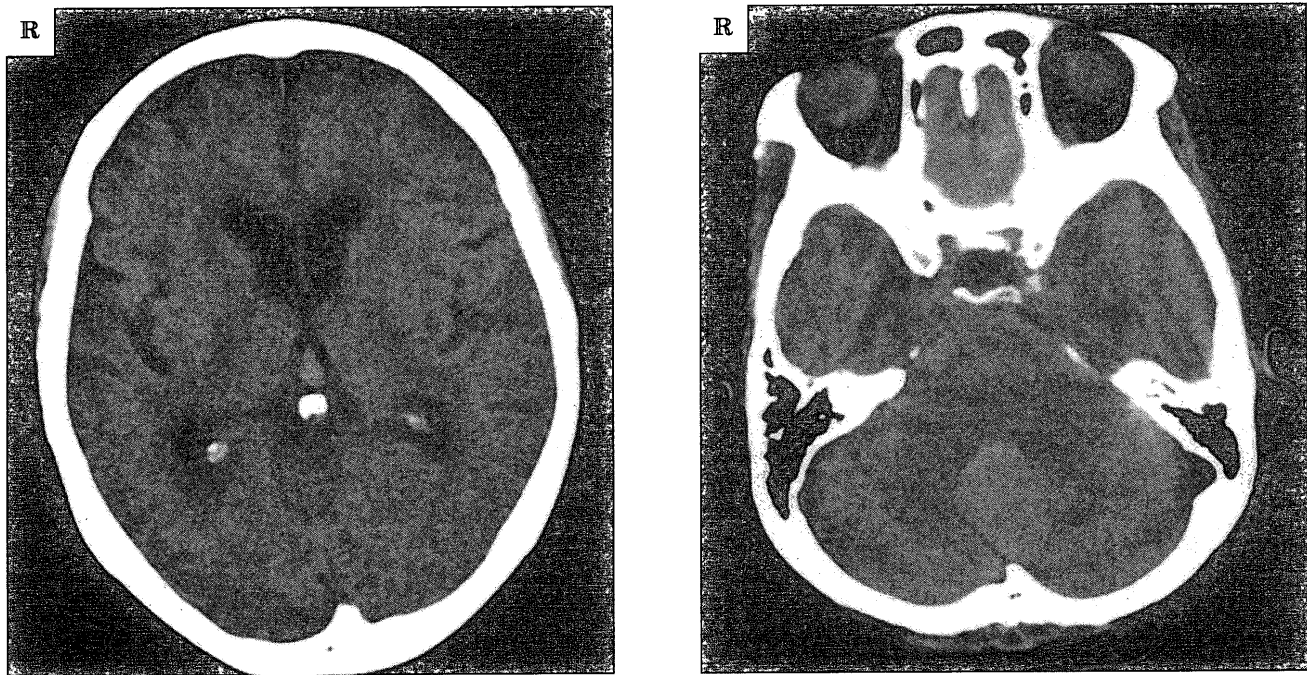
CT scan on admission revealing a hematoma within the fourth ventricle extending into the third ventricle
